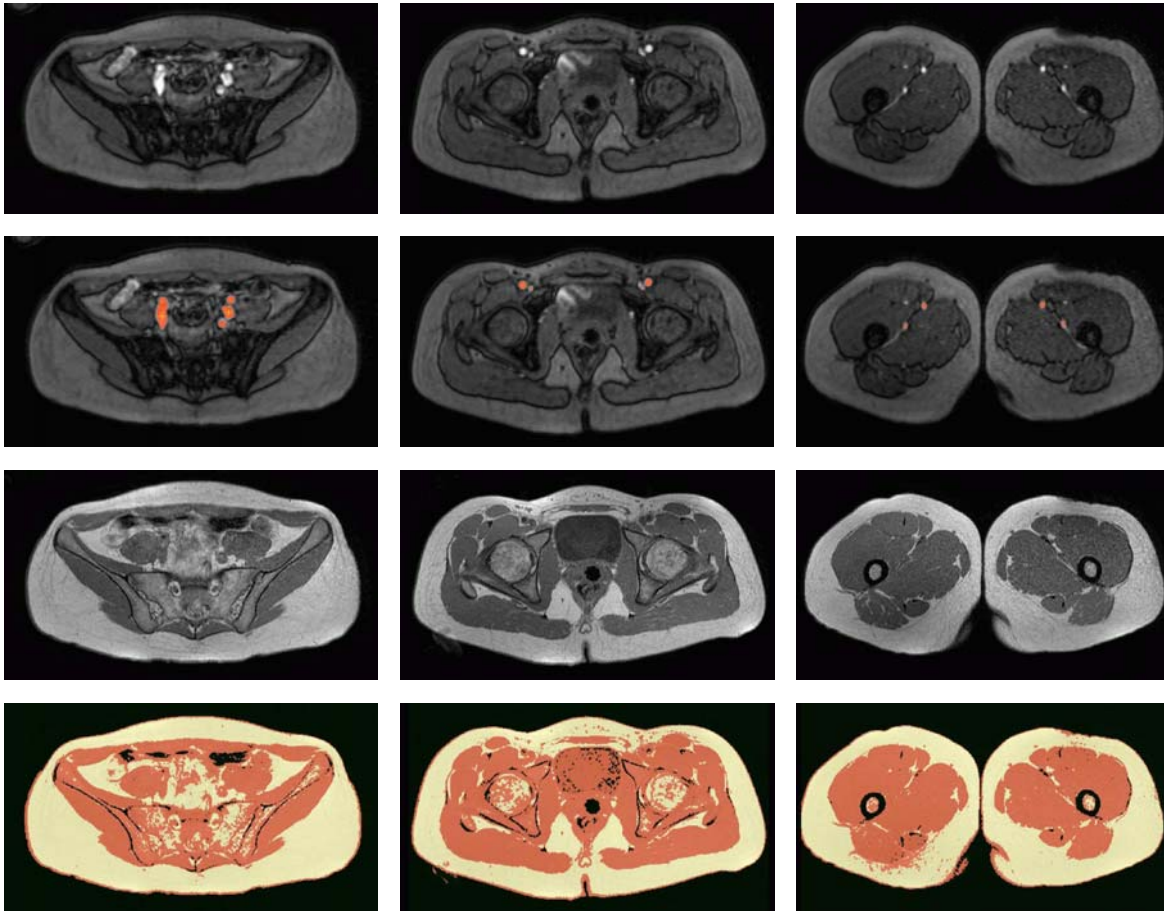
Results: Sample slices from the MRA (*top row*); results for the region growing initialized with a single point in each vessel tree (*2nd row*); corresponding slices from the morphologic MRI (*3rd row*); result of the clustering into three classes: background (black), soft tissue (yellow) and muscle (red) (*bottom row*)
